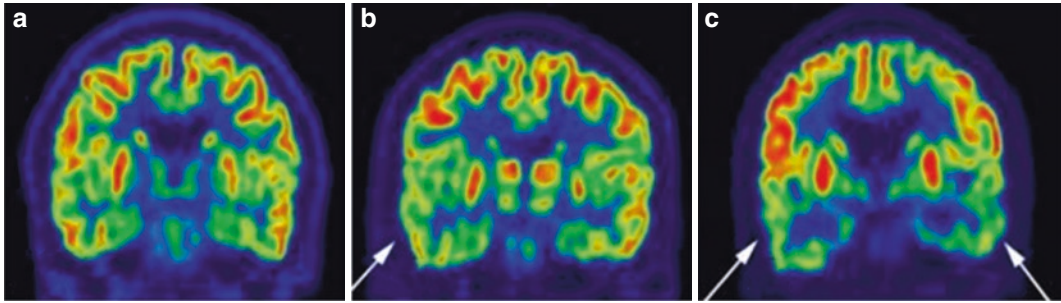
^{18}F -FDG PET imaging of cognitively normal subjects, patients with MCI, and those with AD: A 60-year-old, cognitively normal male subject showing no glucose hypometabolism on ^{18}F -FDG PET imaging (a). A 62-year-old female patient with MCI showing glucose
